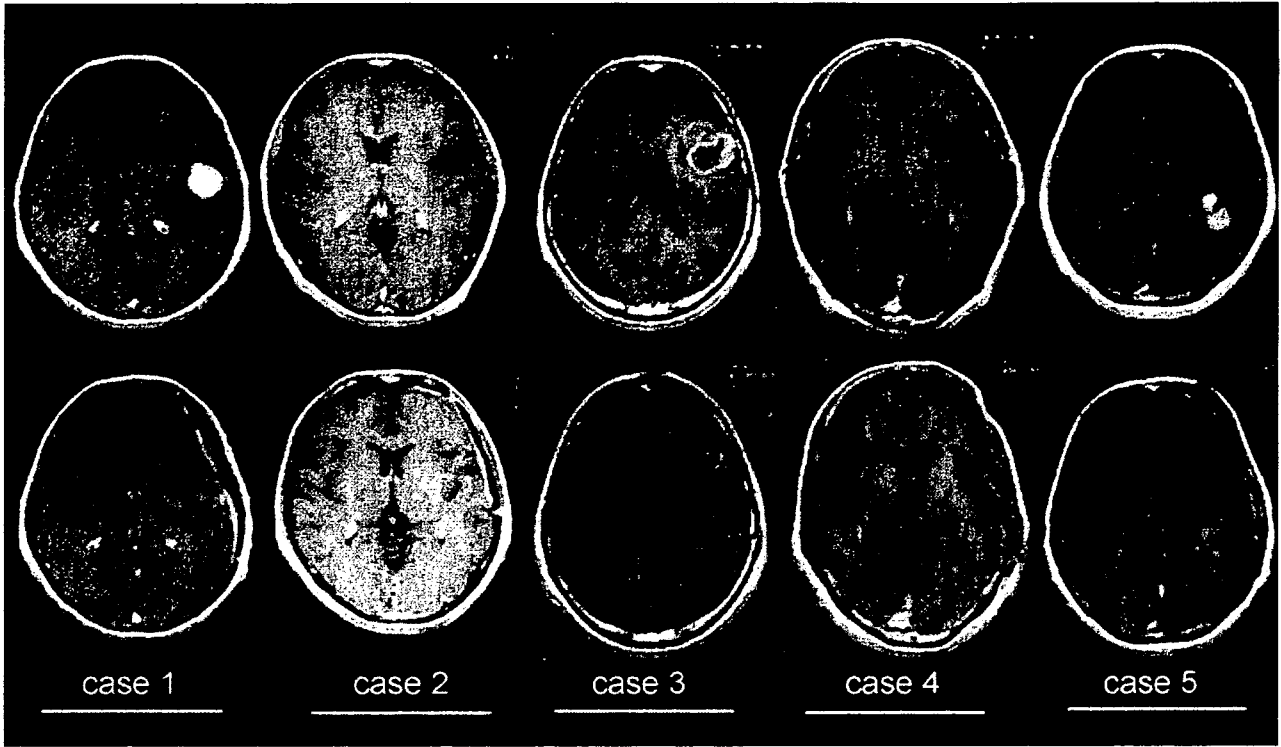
Pre (*upper line*) – and post (*lower line*)-operative Gd-enhanced, T1-weighted magnetic resonance images obtained on the 5 patients. All tumors were removed almost totally
